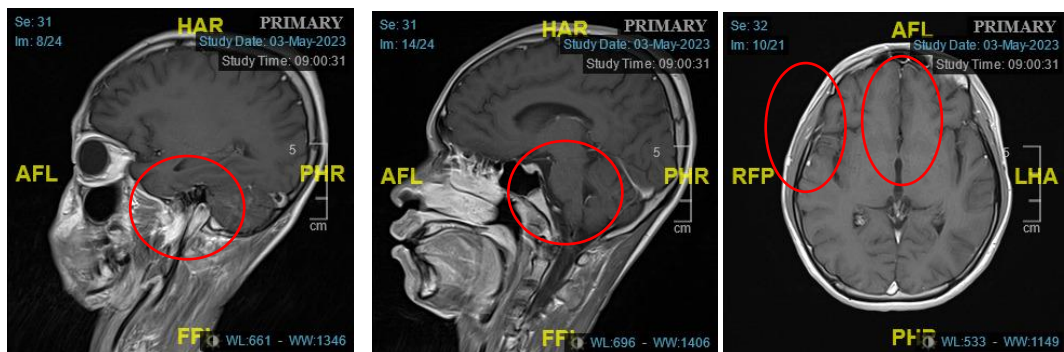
The red circle shows Leptomeningeal enhancement on an MRI of the head with contrast
